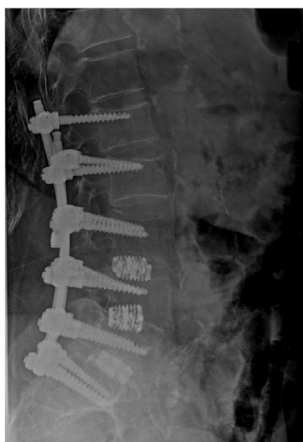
Lateral radiograph following the revision surgery showing L1-S1 spinal fusion with posterior instrumentation.
